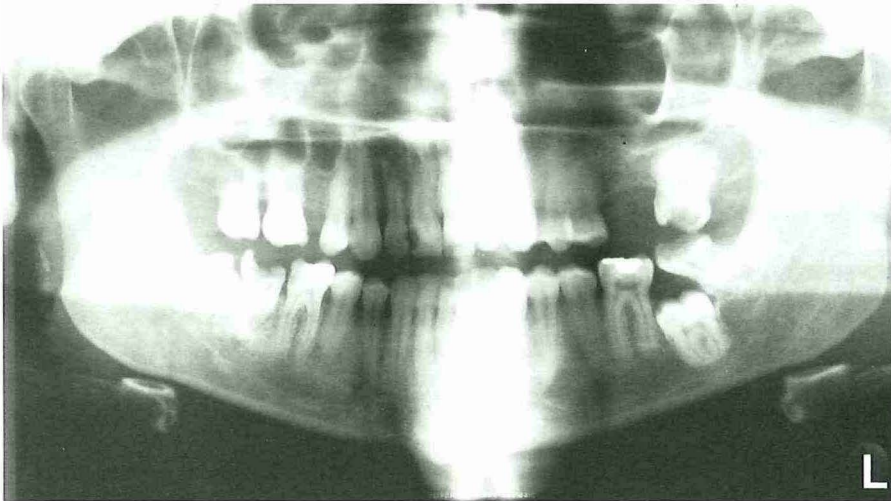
Orthopantomogram of a 26-year-old man showing secondary retention of the mandibular left second molar and severe tilting of the third molar. Both the retained tooth and third molar were removed.
